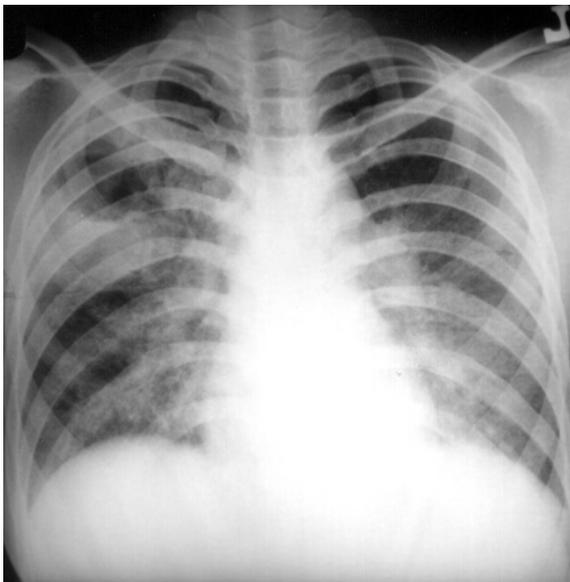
Frontal chest radiograph of a 22-year-old HIV infected woman shows diffuse bilateral reticulonodular opacities with a large, 7-mm thick-walled cavity in the right upper lung
